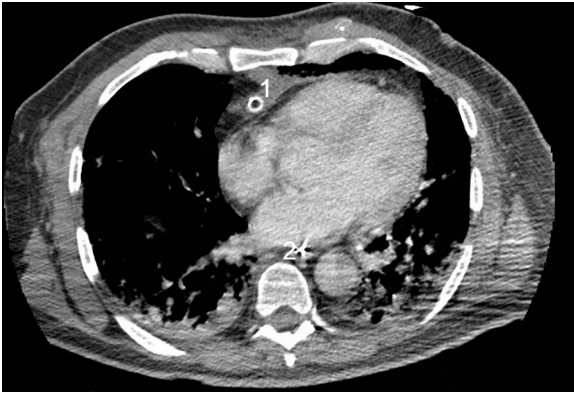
(A) Chest-CT scan of a patient with COVID-19 with a tension pneumomediastinum. (B) Scheme of the surgical incision to decompress the mediastinum.
